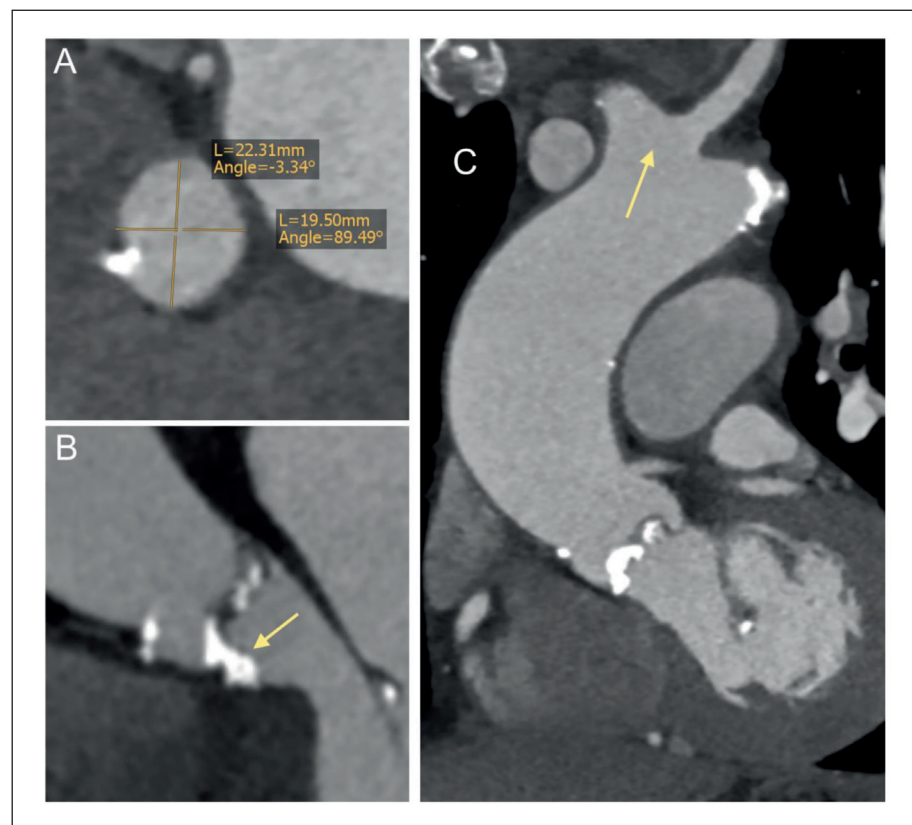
CT scan of patient's annulus.
